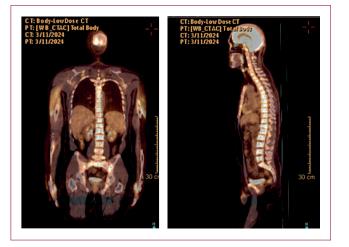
PET-CT scan before treatment (multiple lesions in bones)
